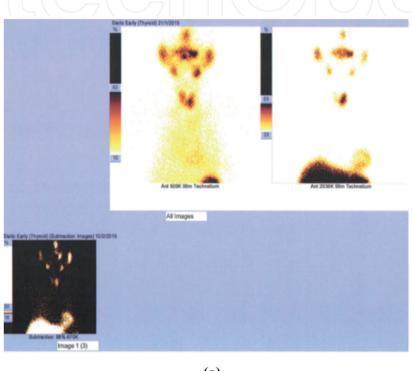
(a) Single-isotope dual-phase scintigraphy with ^{99m}Tc-tetrofosmin. Early planar images (20 min) are with better quality, (b) (same patient) single-isotope dual-phase scintigraphy with ^{99m}Tc-tetrofosmin and (c) ^{99m}Tc-tetrofosmin SPECT images—an area (arroes) with high uptake located dorsally of the lower right lobe is seen, consistent with adenoma of the right lower parathyroid gland.
